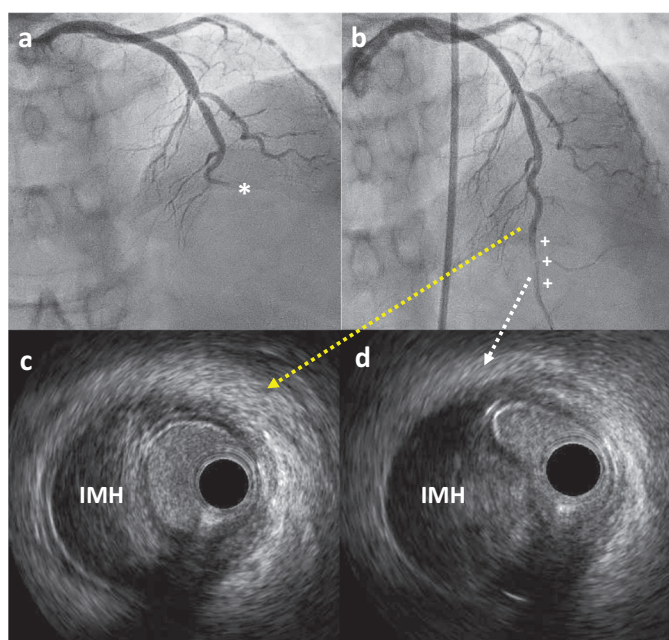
An example of a SCAD lesion with an initial angiographic pattern of complete occlusion (type 4) is shown. (a) Shows an area of complete occlusion in the distal segment of the LAD (white asterisk), with no obvious initial signs of SCAD. (b) After passing an intracoronary guidewire, an image of a double lumen and haziness compatible with SCAD is seen. (c and d) Intravascular ultrasound displays the presence of an intramural hematoma (IMH) (c – angiographically silent, d – causing significant lumen impingement), confirming the diagnosis of SCAD.
